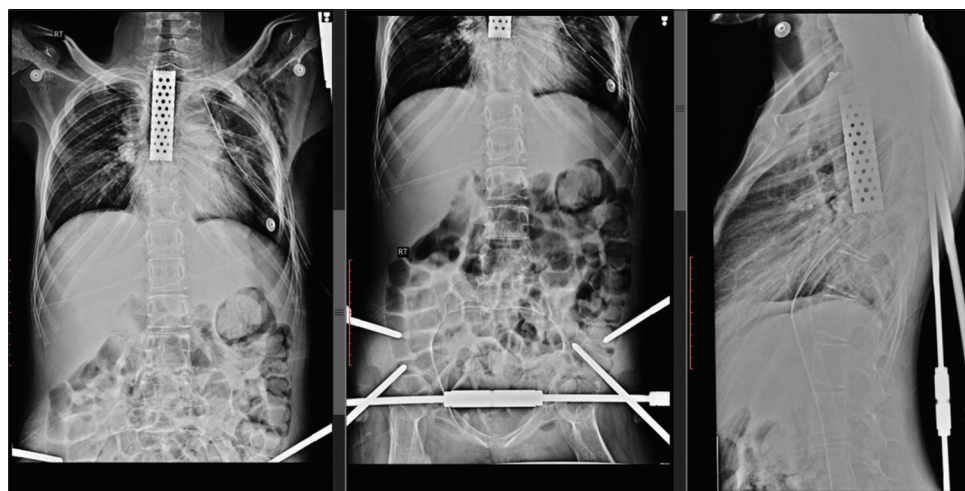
Radiographic images taken just after corrective surgery showing placement of thoracic cage from T1 to T10.
